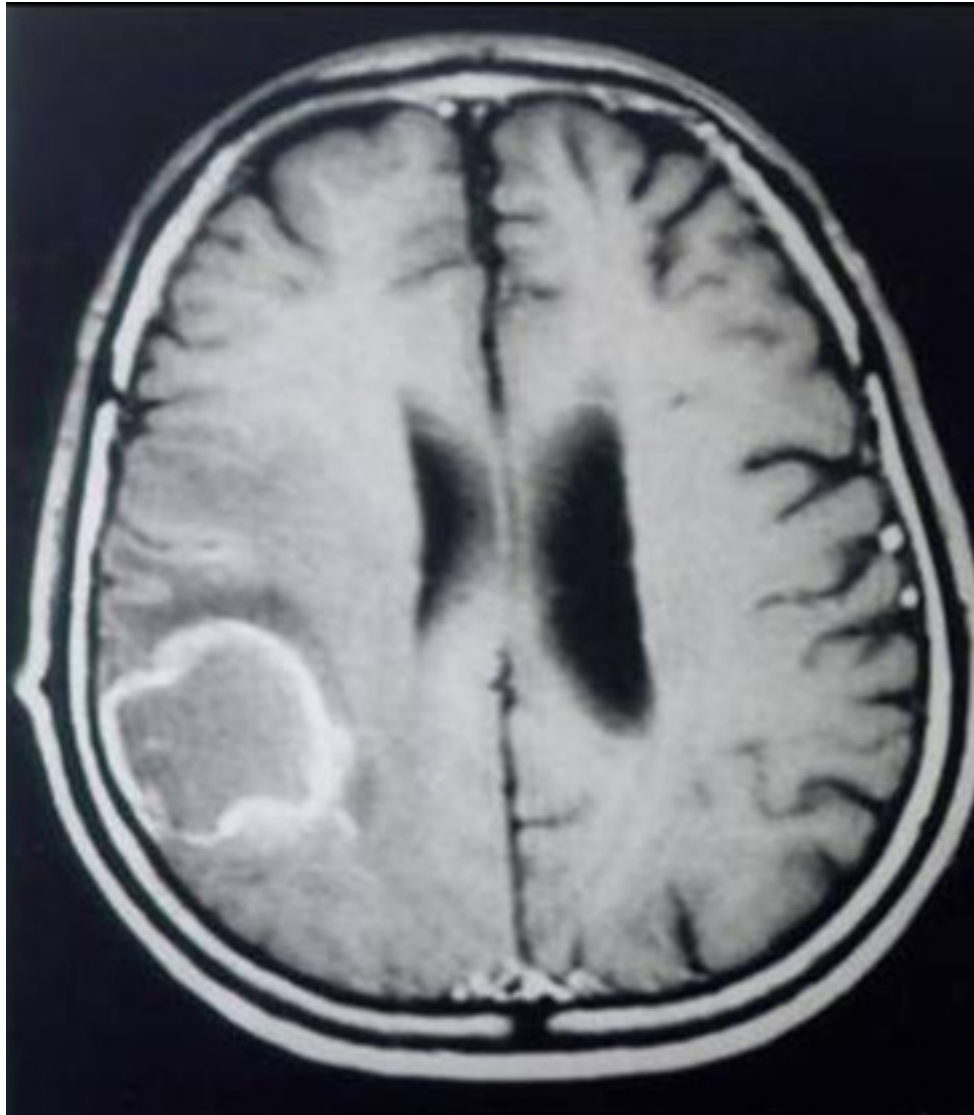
MRI brain in a patient with AIDS and reactivation of Chagas disease in CNS
